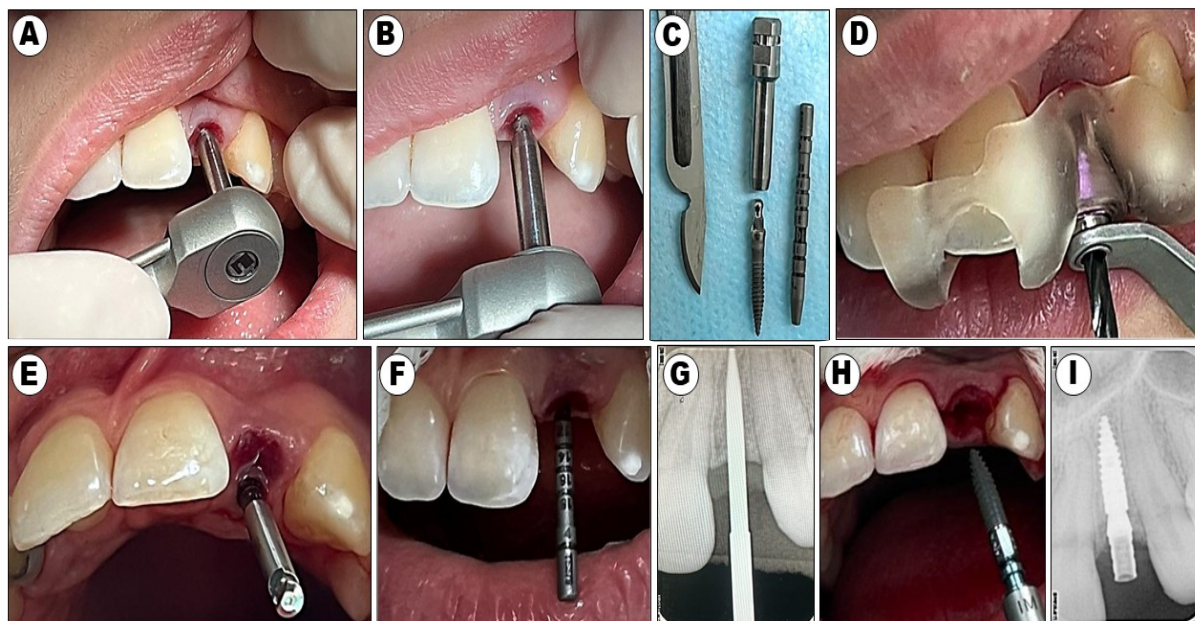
A: Removal of the temporary implant in region 22 with the aid of an orthodontic mini-screw hexagonal wrench - Adaptation of the component on the head of the temporary implant B: Application of reverse torque on the ratchet to remove the temporary implant C: View of the temporary implant immediately after removal D: Surgical guide in position for drilling with a lance drill E: Milling with a 2.2 drill F: Evaluation of the drilling with the parallelometer G: Trans and post operative periapical radiographs of region 22 - Parallelometer in position to assess the positioning of the drilling H: Installation of the BLT Ø 2.9x10mm SC, SLActive®, Roxolid® implant using the hybrid technique I: Immediate postoperative period after implant placement - Oval temporary abutment for crown
